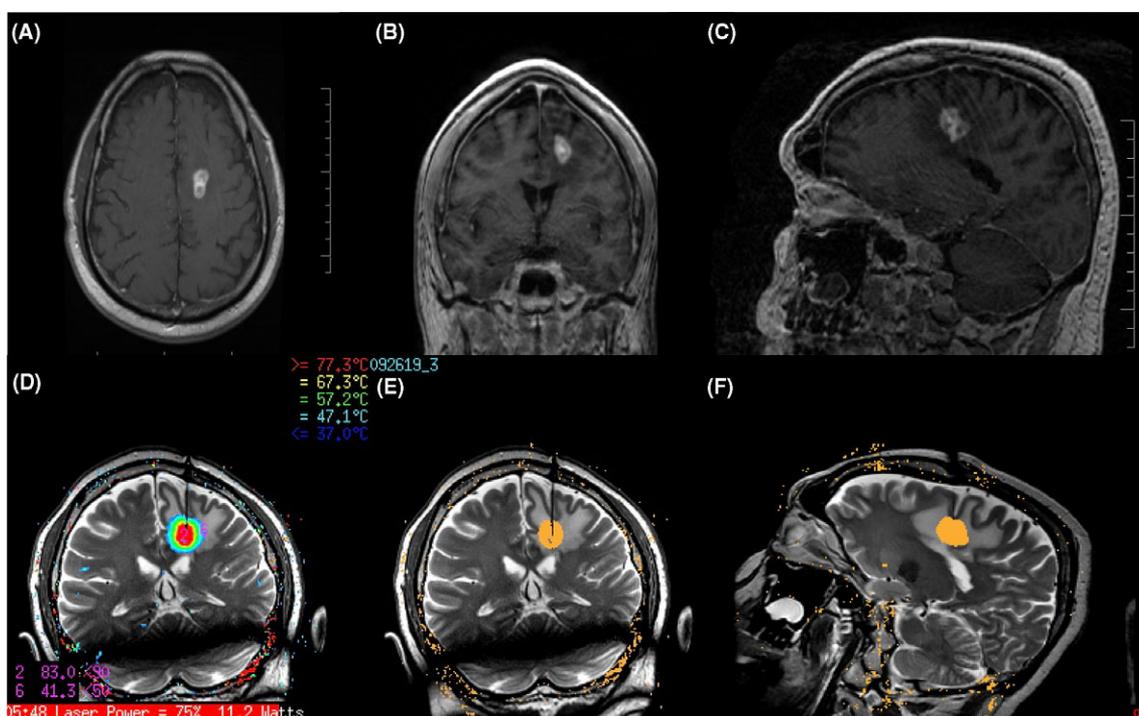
Laser interstitial thermocoagulation therapy (patient treated in the Toronto Western Hospital). Preoperative MRI (post-gadolinium) demonstrating an enhancing left frontal mass with surrounding edema in a patient with a known primary sarcoma in an axial (A), coronal (B), and sagittal (C) plane. Real-time effects of the interstitial laser heating target tissue visualized via MRI thermography (D) and the subsequent zone of irreversible target ablation outlined in orange (E, F). The thin artifact of the laser catheter, inserted via a 2–3 mm incision, can be seen (D, E).
